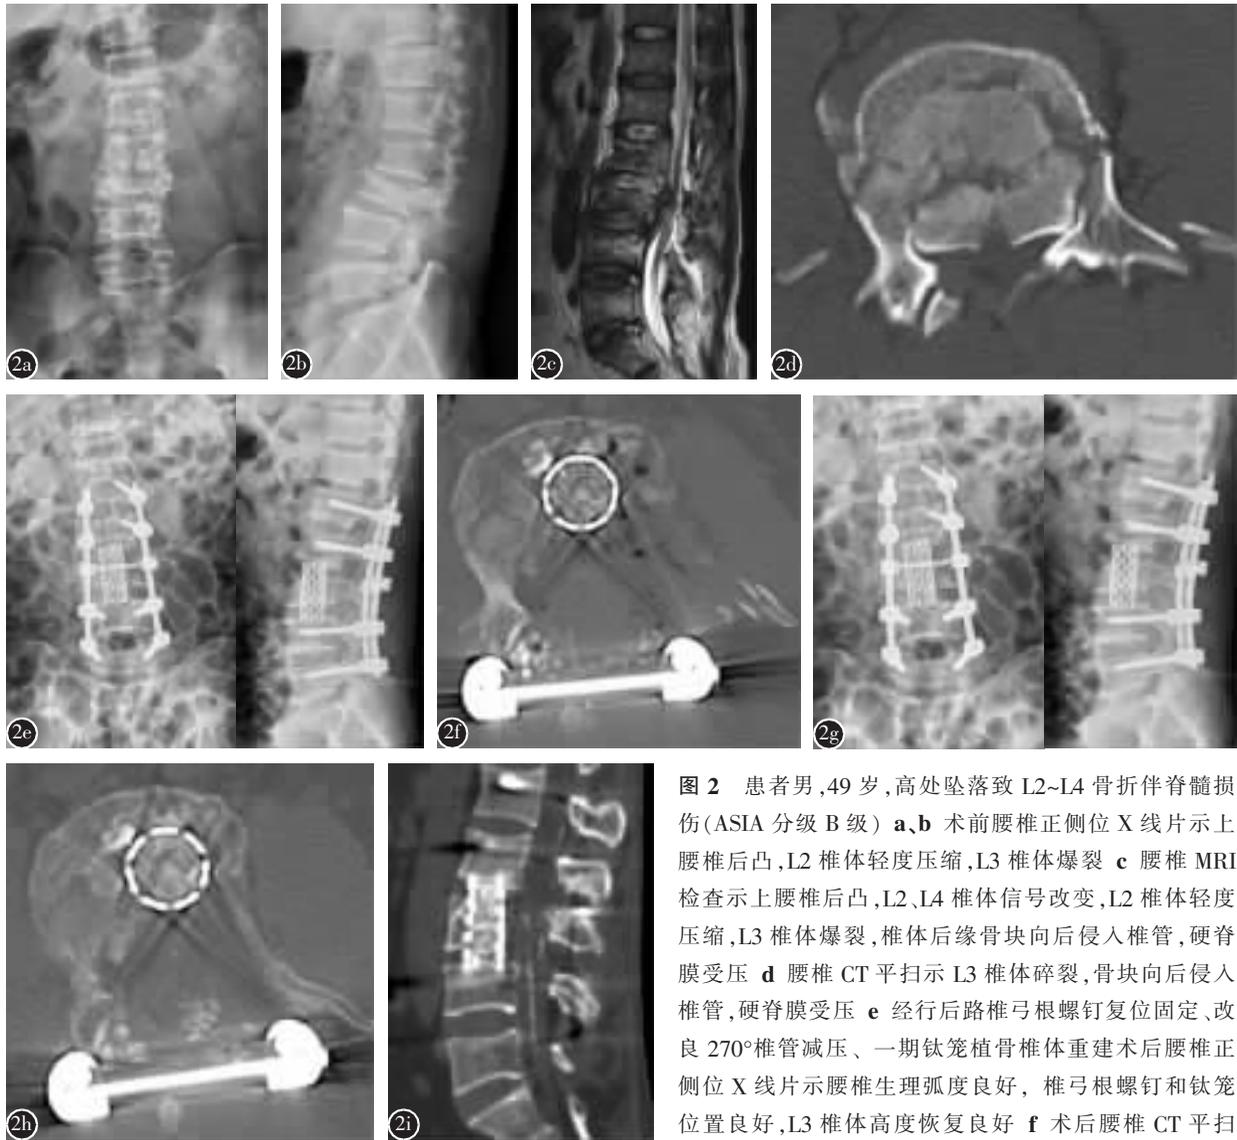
患者男,49 岁,高处坠落致 L2~L4 骨折伴脊髓损伤(ASIA 分级 B 级) a,b 术前腰椎正侧位 X 线片示上腰椎后凸,L2 椎体轻度压缩,L3 椎体爆裂 c 腰椎 MRI 检查示上腰椎后凸,L2、L4 椎体信号改变,L2 椎体轻度压缩,L3 椎体爆裂,椎体后缘骨块向后侵入椎管,硬脊膜受压 d 腰椎 CT 平扫示 L3 椎体碎裂,骨块向后侵入椎管,硬脊膜受压 e 经行后路椎弓根螺钉复位固定、改良 270°椎管减压、一期钛笼植骨椎体重建术后腰椎正侧位 X 线片示腰椎生理弧度良好,椎弓根螺钉和钛笼位置良好,L3 椎体高度恢复良好 f 术后腰椎 CT 平扫示椎管减压良好 g 术后 1 年腰椎正侧位 X 线片示椎
